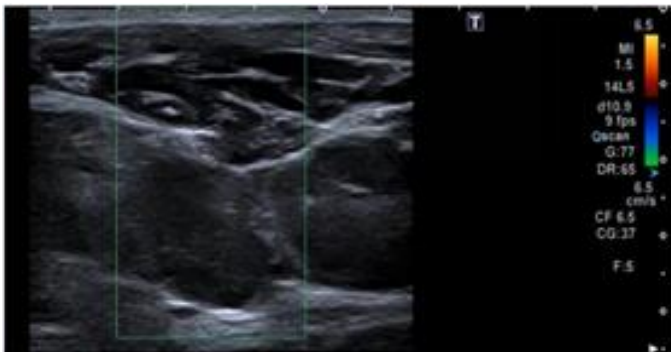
showing no blood flow on colour doppler
